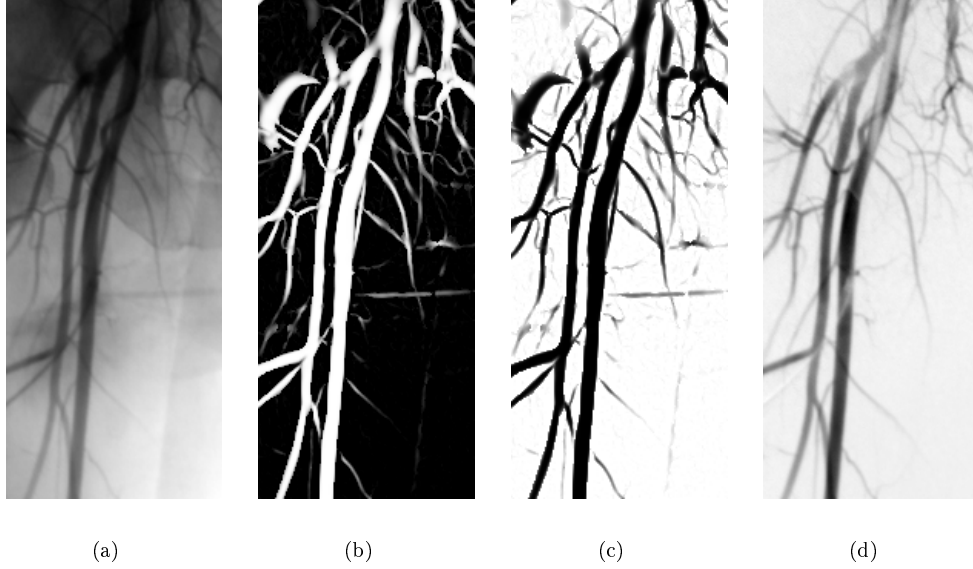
a)* Part of a contrast X-ray image of the peripheral vasculature. *b)* Calculated vessel likeliness of the left image. *c)* Calculated vessel likeliness after inversion of the grey-scale map. *d)* Image obtained by subtracting reference (without contrast) image from left image; shown here to facilitate visual inspection of the results of the filtering procedure.
